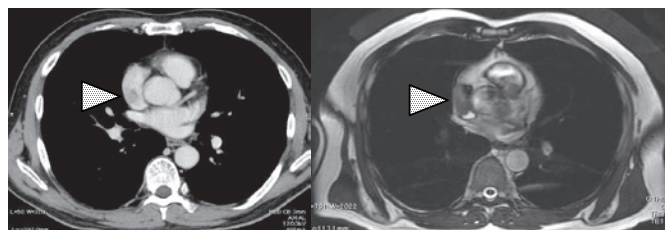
Left, Chest CT showed the tumor in the right atrium. Right (arrowheads), T1-weighted MRI of the chest also showed the tumor in the left atrium (arrowheads).
